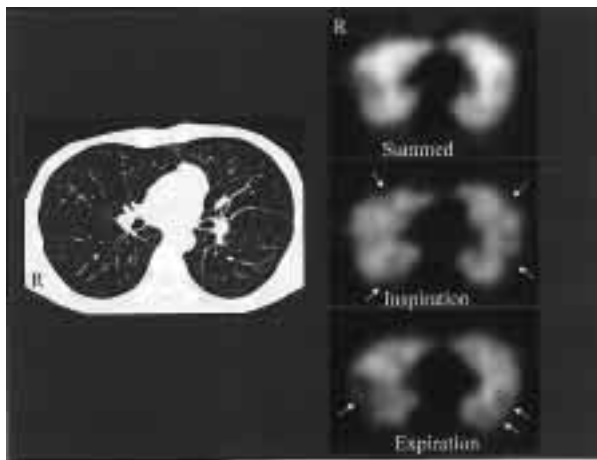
Respiratory-gated Technegas SPECT study in a 56-year-old patient with acute bronchiolitis. The chest CT image at the lung level corresponding to the SPECT images shows only focal tiny opacities along the peripheral bronchi. Although the conventional summed SPECT image shows ventilation deficits mainly along the peripheral lung areas, these ventilation deficits are more discrete on the matched inspiration and expiration phase SPECT images (*arrows*).
